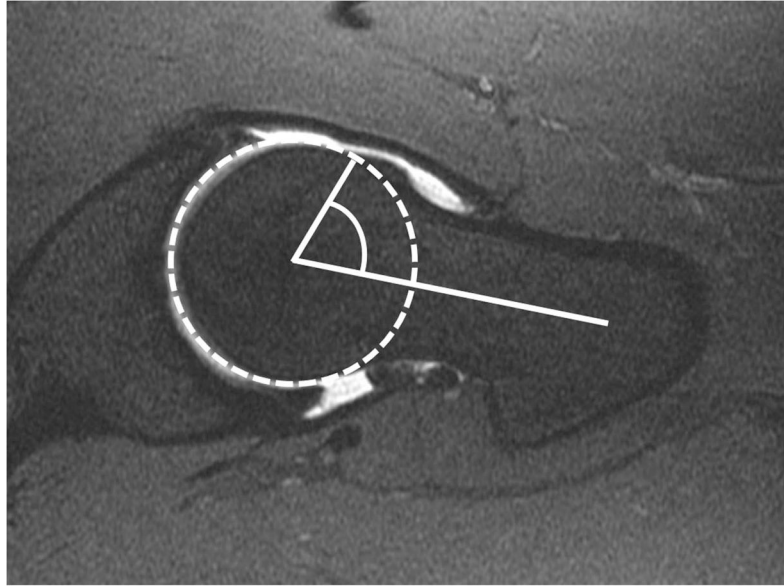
Axial oblique fat-saturated T1-weighted MR arthrographic image showing measurement of the alpha angle. A circle is drawn around the femoral head and articular cartilage. The alpha angle is formed between a line along the center of the femoral neck and a second line from the center of the femoral head to the point at which the bony contour of the femoral head-neck junction extends outside the circle.
